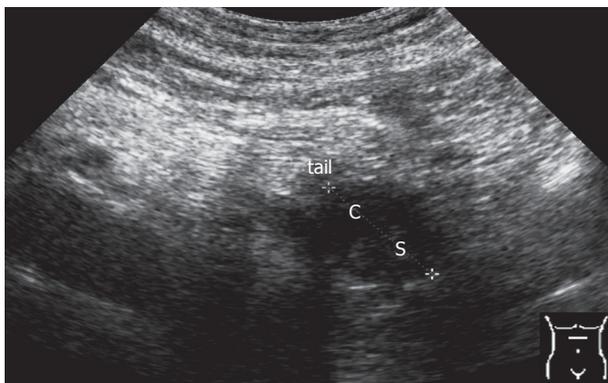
Cystadenoma at conventional and echo-enhanced ultrasound A: A tumour (7 cm in diameter) at the pancreatic tail with large cystic (c) and solid areas (s); B: A poorly vascularized solid (s) tumour (maximum of contrastation 15 s after injection of the echo-enhancer).
